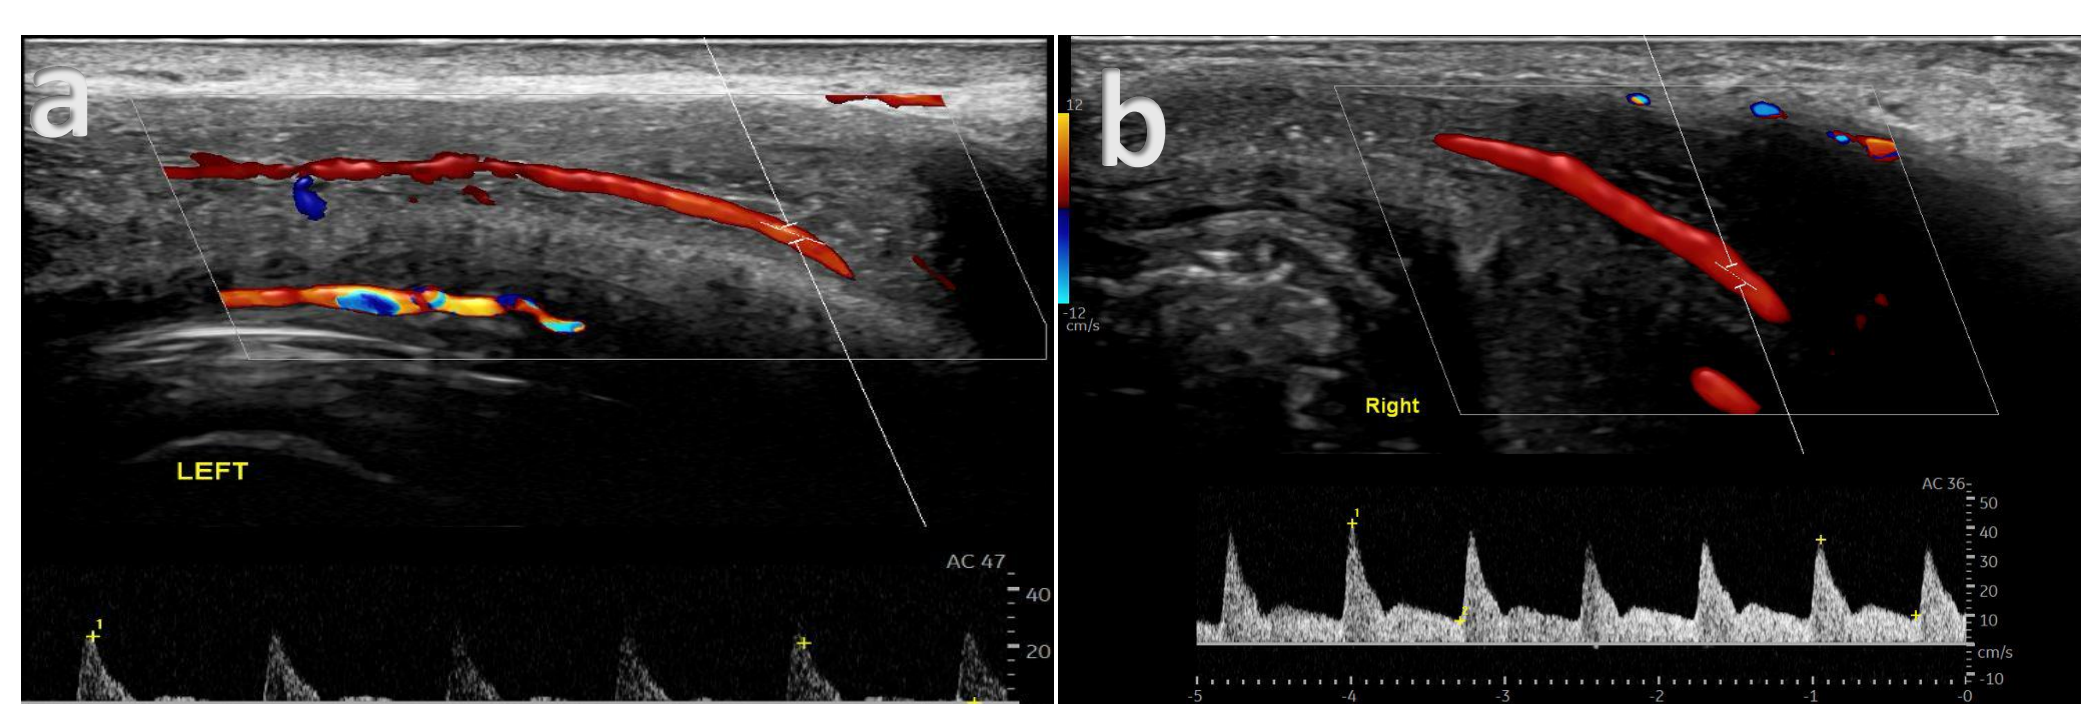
Erectile dysfunction. (a) Spectral Doppler of the penis acquired 25 mins post injection with the PSV being 23.6 cm/s. (b) Venous leak - 20 mins post injection with a PSV of 41 cm/s and a persistently elevated EDV of 10 cm/s.
